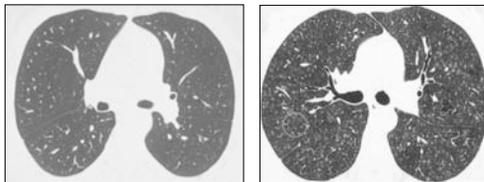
A high-resolution CT image (HRCT). On the left are normal lungs, on the right the patient's lungs. Here you can clearly see these so-called diffuse defects (medical term: 'extrinsic allergic alveolitis').
